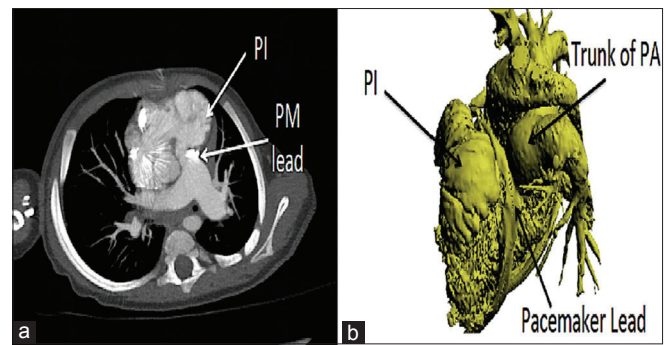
Cardiac computed tomography scan (a) and its three-dimensional model (b): Generated using Materialise Mimics (version 18.0 × 64 bit), showing infundibular dilatation and compression under the pulmonary valve by pacemaker leads. PA: Pulmonary artery, PI: Pulmonary infundibulum, PM: Pacemaker
